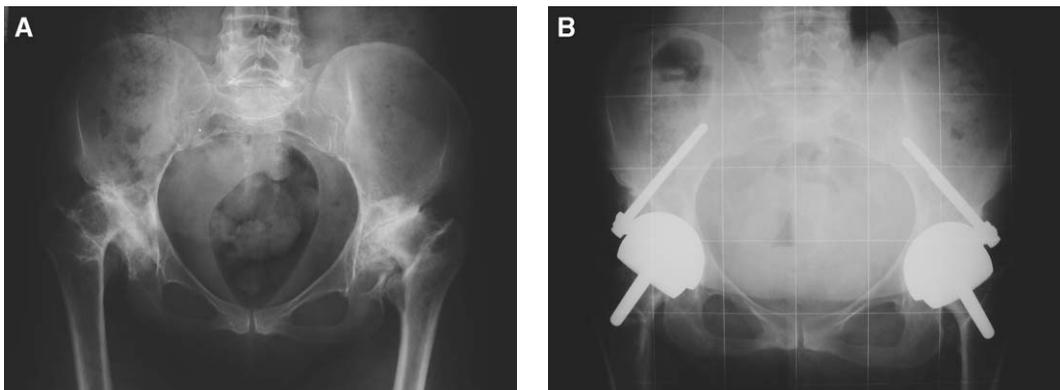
Bilateral dysplasia BHR. (A) Preoperative x-ray. (B) Postoperative x-ray at 3 years.
